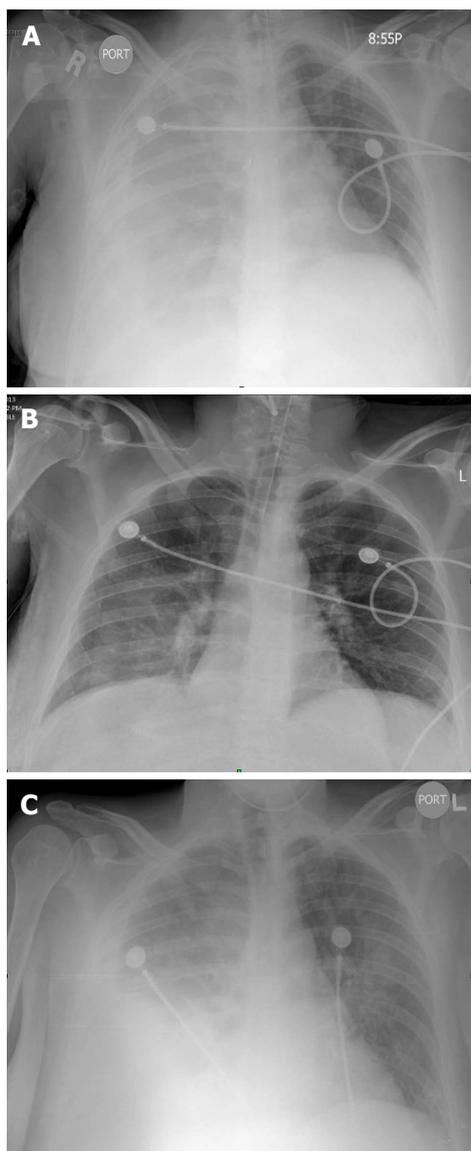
Pre-ventilation, ventilation and post-ventilation chest X-ray films in chronological order. A: Chest X-ray taken immediately after intubations showing complete opacification of right hemithorax from a massive pleural effusion; B: Chest X-ray taken a day after the intubation showing near-complete resolution of the right sided pleural effusion; C: Chest X-ray taken after extubation showing recurrence of the right sided pleural effusion.
